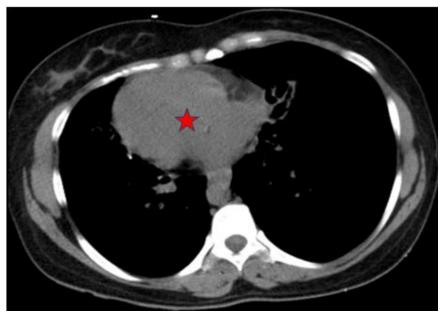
Axial section CT scan of chest showing dextrocardia (asterisk)
